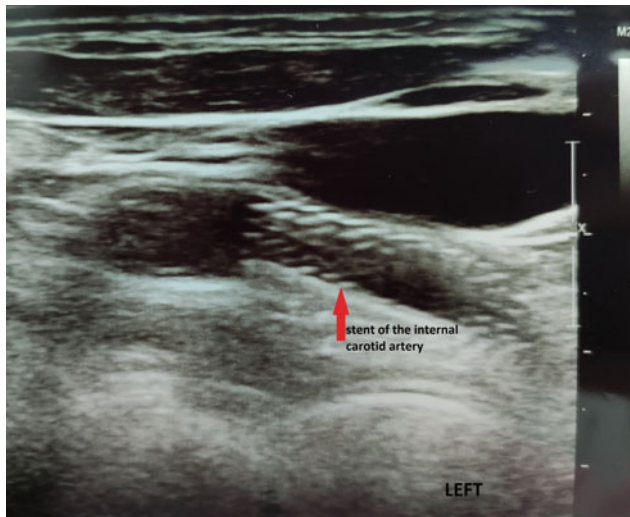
Duplex ultrasound. 25–30% stenosis in the stented internal carotid artery
